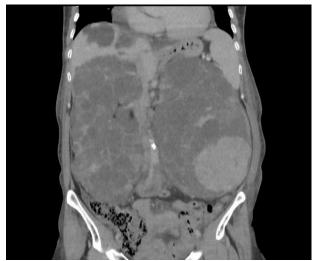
CT urography with enlarged polycystic kidneys and minimal visible parenchyma
